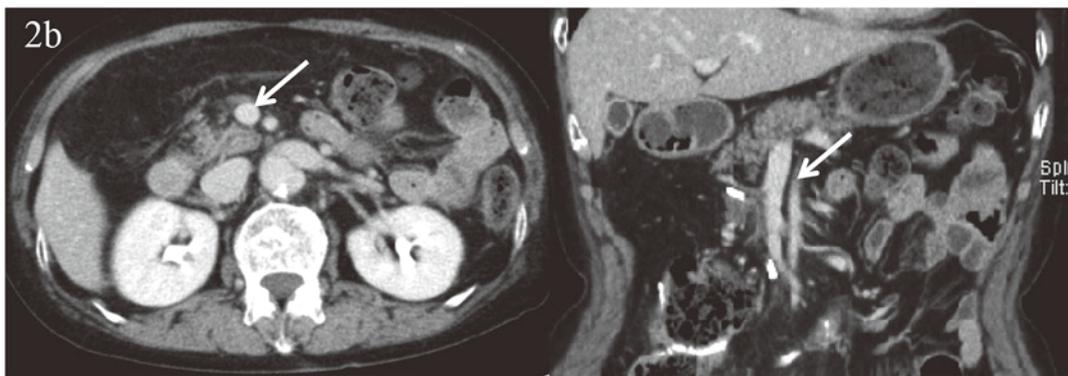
Contrast-enhanced computed tomographic images of the abdomen from postoperative day 56 showed complete disappearance of the thrombus (arrows).
